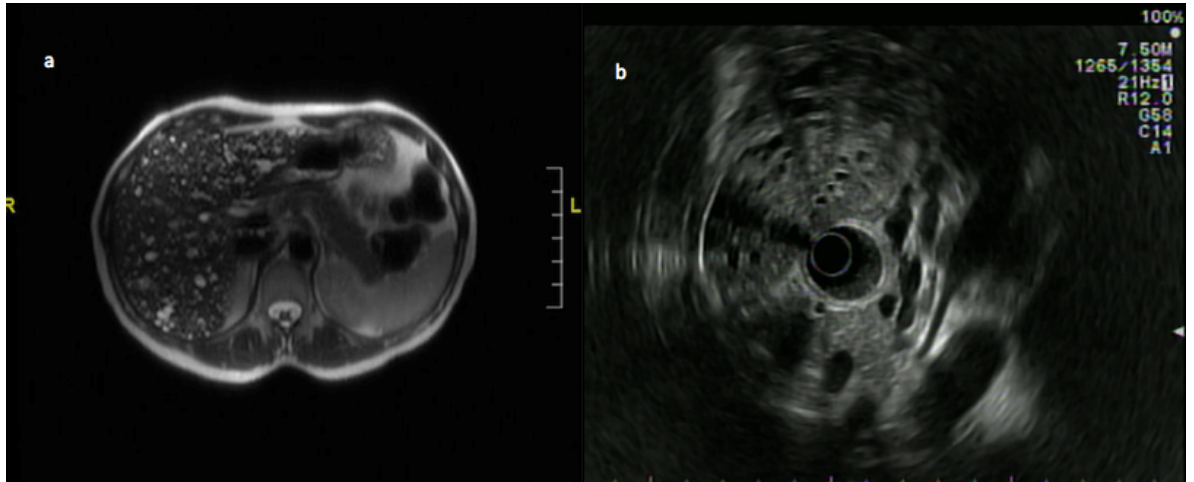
A. T2-weighted magnetic resonance image showing multiple small hyper-intense lesions. B. EUS image of the left hepatic lobe with rounded anechoic formations secondary to a dilated bile canaliculi.
